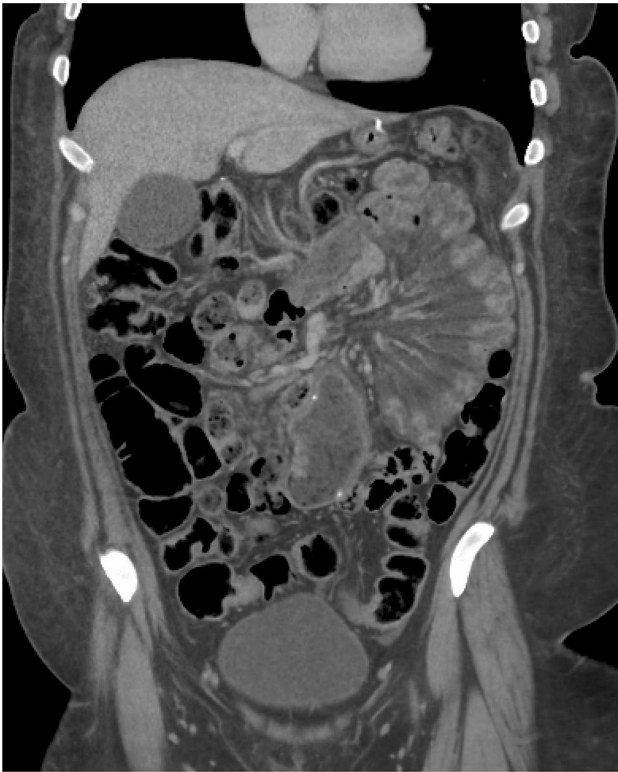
35-year-old female with surgical history of gastric bypass presenting with abdominal pain. Initial TVUS (not shown) was interpreted as normal. Coronal contrast-enhanced CT demonstrates a radial configuration of congested small bowel loops in the left upper quadrant with prominent mesenteric edema in a configuration concerning for internal hernia, which was confirmed at surgery
